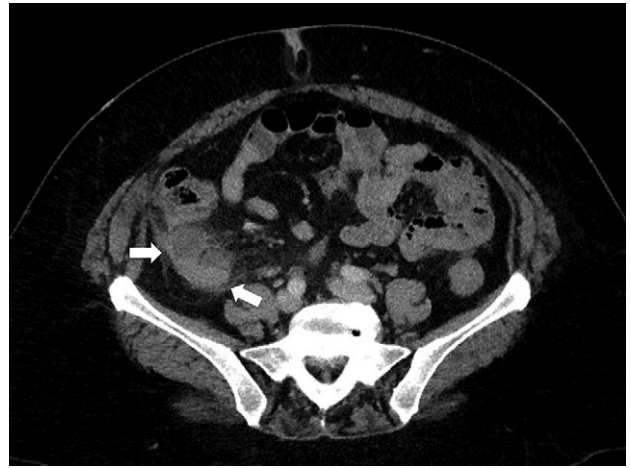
Abdominal CT of Case 2. Markedly thickened retrocaecal appendix with associated periappendiceal fat stranding. Associated with the body of the appendix is a collection located posterior to the ascending colon (arrows).
